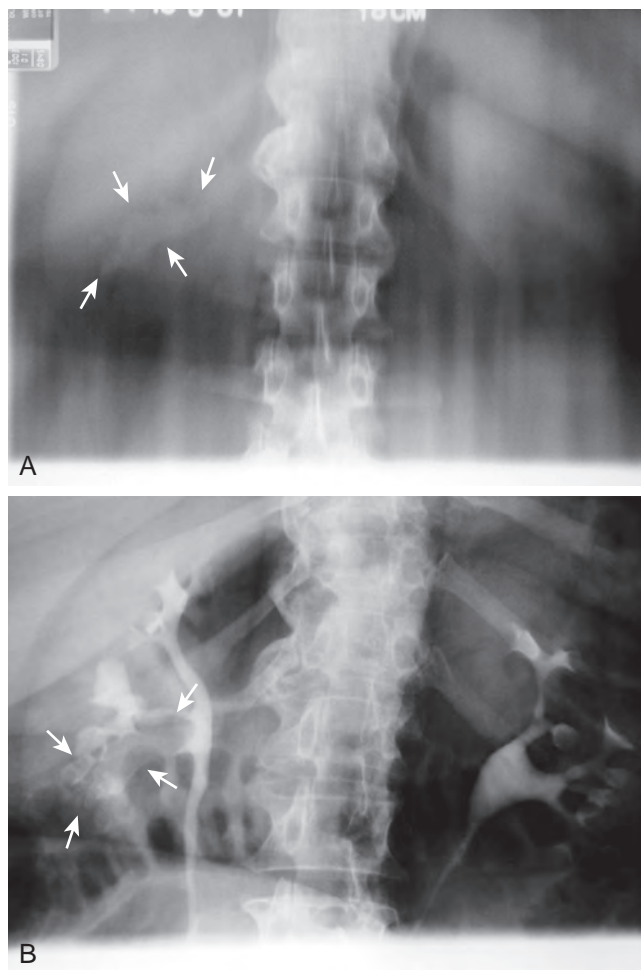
A, Plain film tomographic appearance of a lower pole partial staghorn uric acid calculus (arrows). B, The addition of intravenous contrast demonstrates the stone as a “filling defect” (arrows) during the excretory portion of the intravenous pyelogram.
